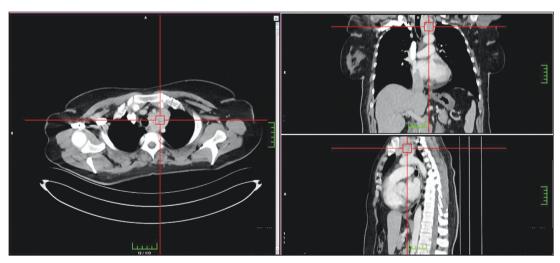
Computed tomography image of paraganglioma.
